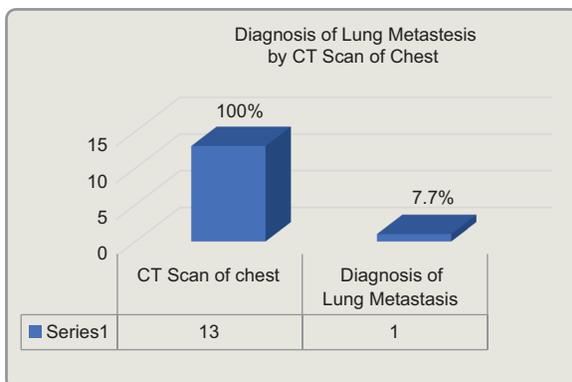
Diagnosis of lung metastases by CT scan of chest.
